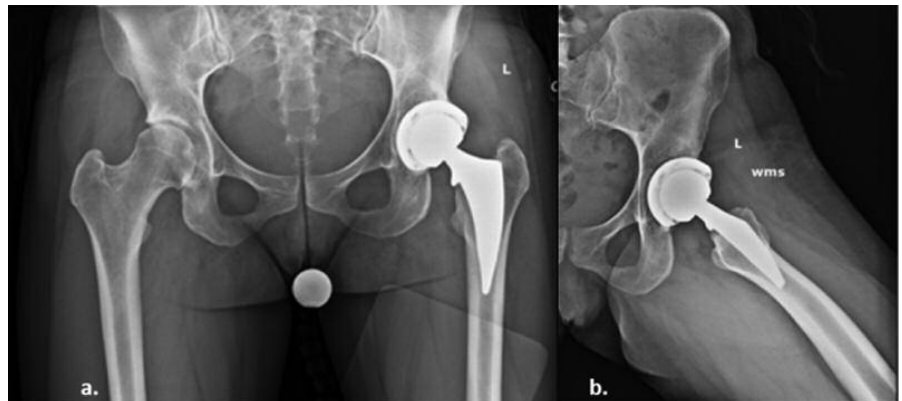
Example of an AP pelvis (a) and frog-leg lateral hip radiograph (b) of the Medacta SMS at the six-week postoperative visit.
